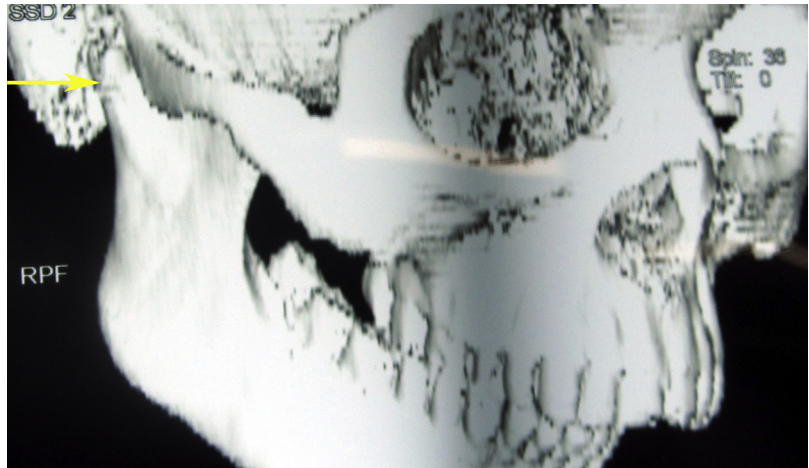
Three-dimensional CT image showing superolateral dislocation of the right condyle (yellow arrow).
